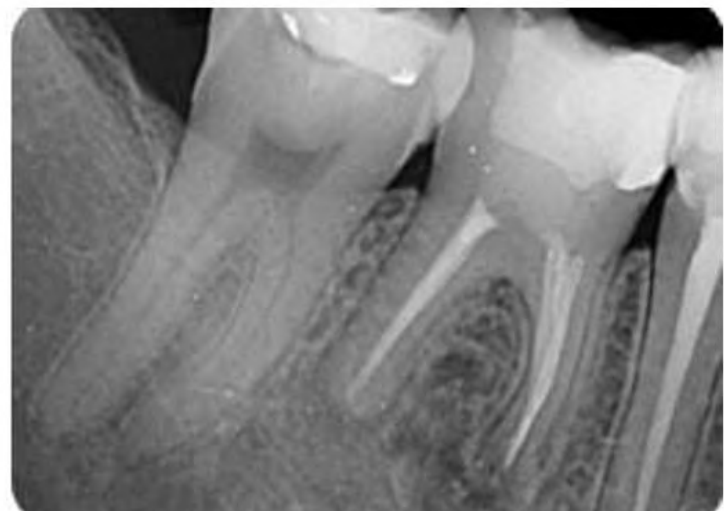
X-ray right after endodontic surgery
